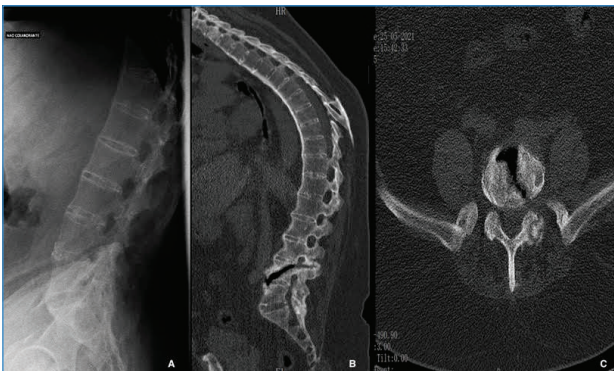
X-ray and computed tomography of the lumbar spine
